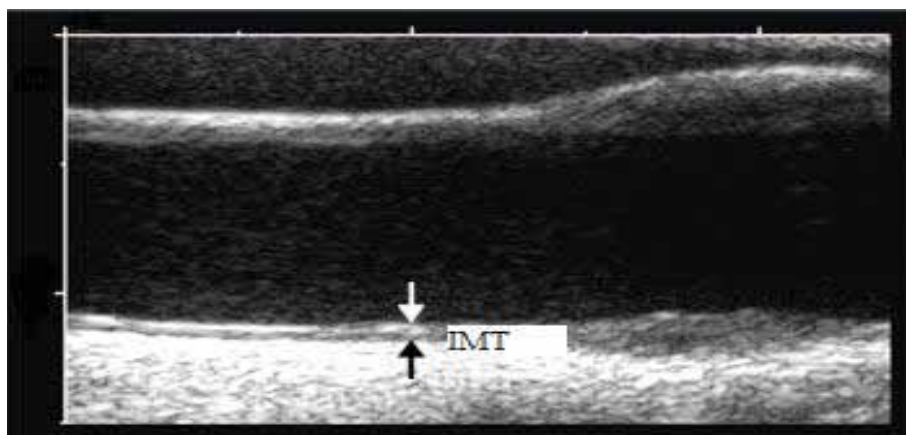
IMT image on ultrasound mode B
